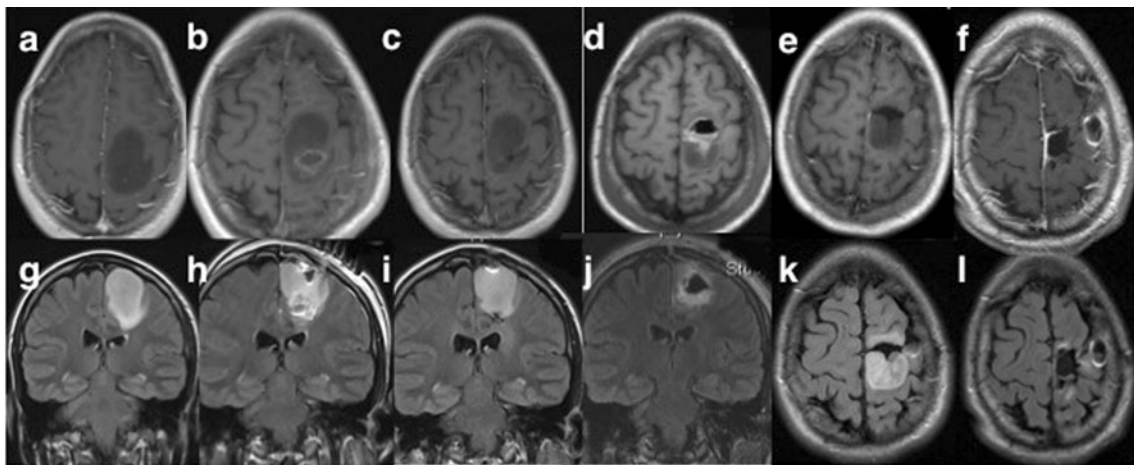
Chronological change in MRI findings of the tumour a–f: T1-weighted MR image with intravenous injection of gadolinium (Gd) of the tumour, g–l: FLAIR MR-image of the tumour, a and g: at the time of initial presentation of the patient, b and h: immediately after the first
